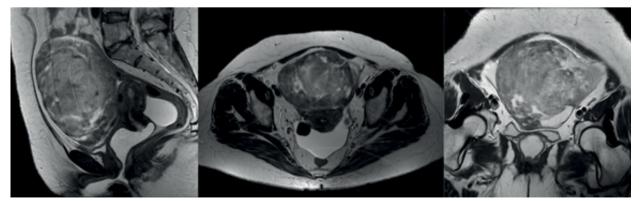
Coronal and axial T2 magnetic resonance images showing a large solid lesion, located in the abdominal-pelvic transition, superiorly to the urinary bladder and anteriorly to the uterus without invasion of adjacent structures
